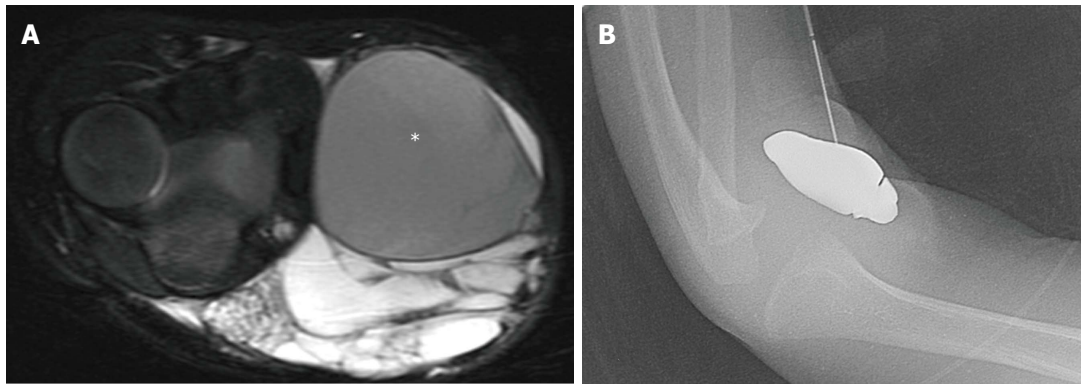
Macrocytic lymphatic malformation with hemorrhage. Axial fat suppressed T2 weighted magnetic resonance image of the elbow (A) demonstrates a predominantly hyperintense malformation with hypointense hemorrhage in a loculation (asterisk). Direct access to the malformation is obtained with a 22-gauge needle for sclerosis (B), subsequently performed with doxycycline.
